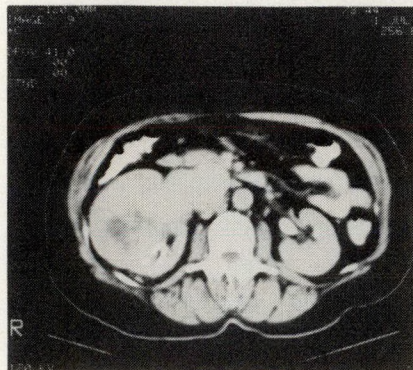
Case 1. Preoperative abdominal computed tomogram demonstrating large right renal mass extending into inferior vena cava.
